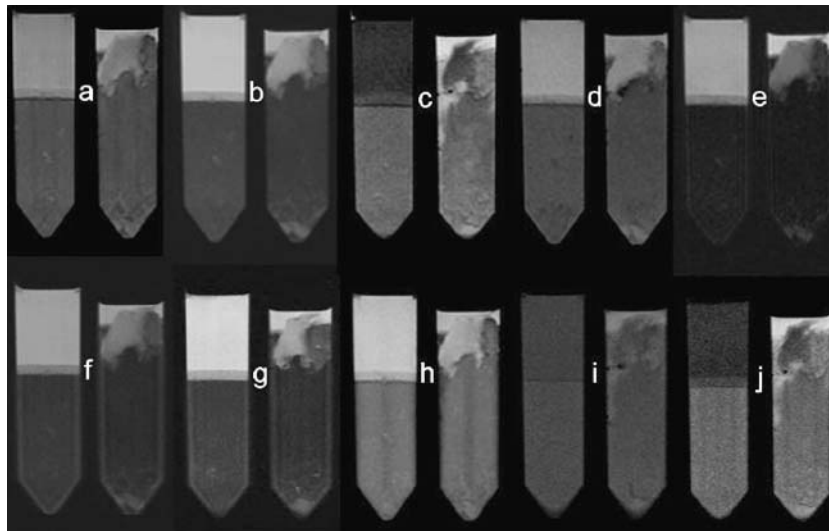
a-j Sedimented blood (*left*) and blood with postmortem clotting (*right*) in ten of the most used MRI sequences in postmortem imaging showing the differences in contrast at room temperature (22°C). a PD-weighted (TE 15 ms, TR 4,000 ms), b T2-weighted (TE 90 ms, TR 4,000 ms), c T1-weighted (TE 14 ms, TR 400 ms), d gradient recalled at steady state sequence (TE 8 ms, TR
